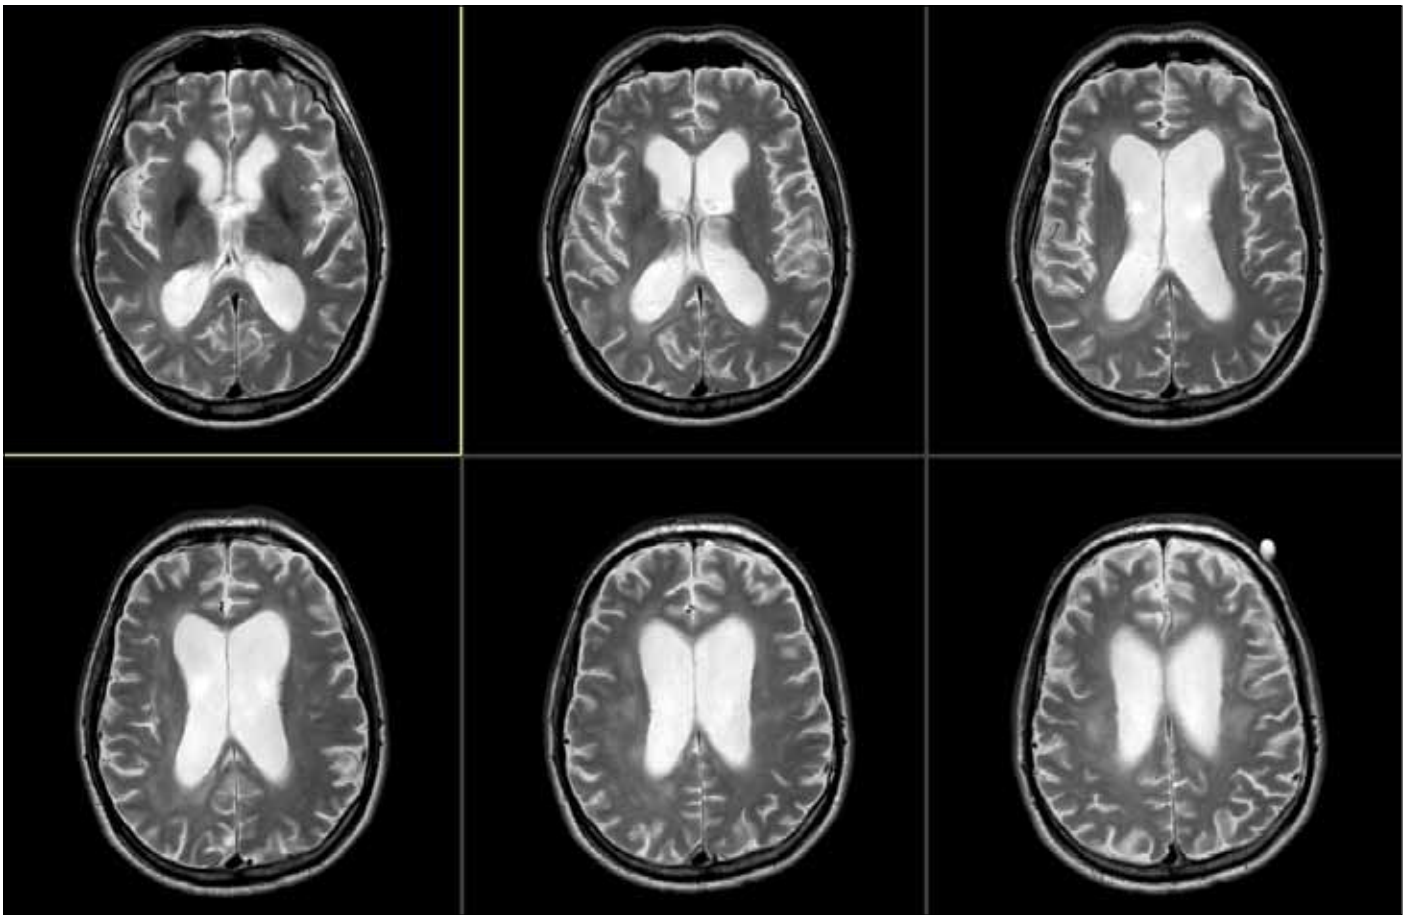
Magnetic resonance imaging brain scan showing dilated ventricles and atrophy typical of HIV dementia.
